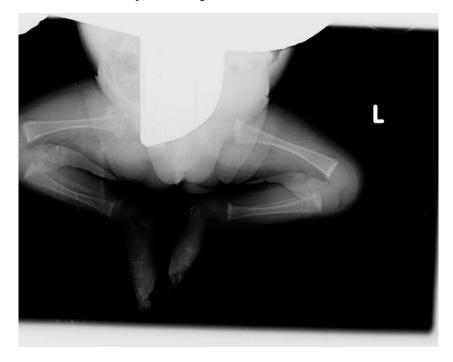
The X-ray of the proximal right femoral showing areas of osteolysis and massive periosteal reaction
